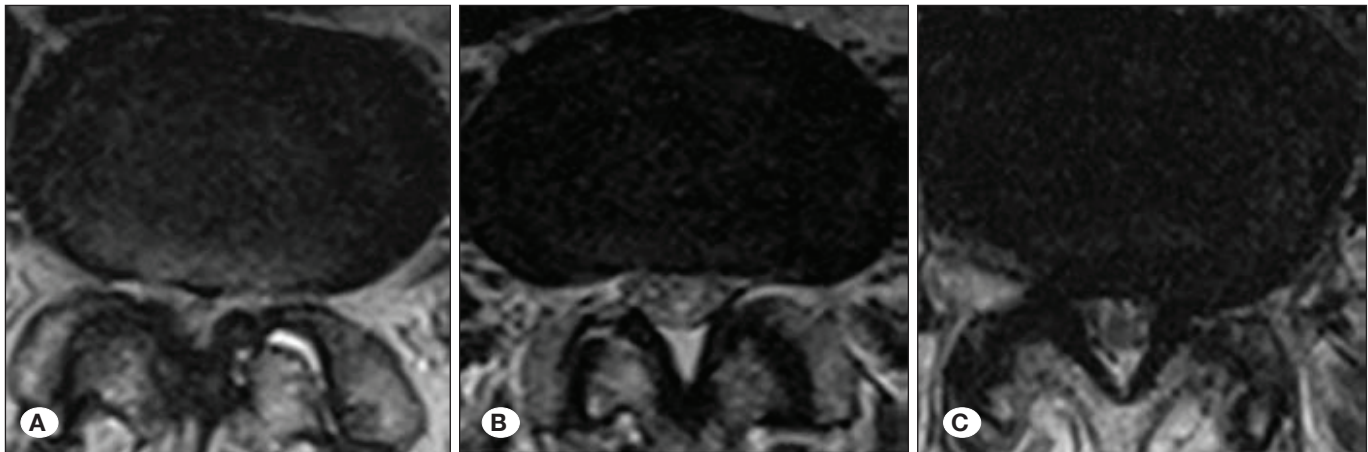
T2 Magnetic resonance images of oval (A), round (B), and trefoil (C) shaped spinal canal shapes and spine structure.
